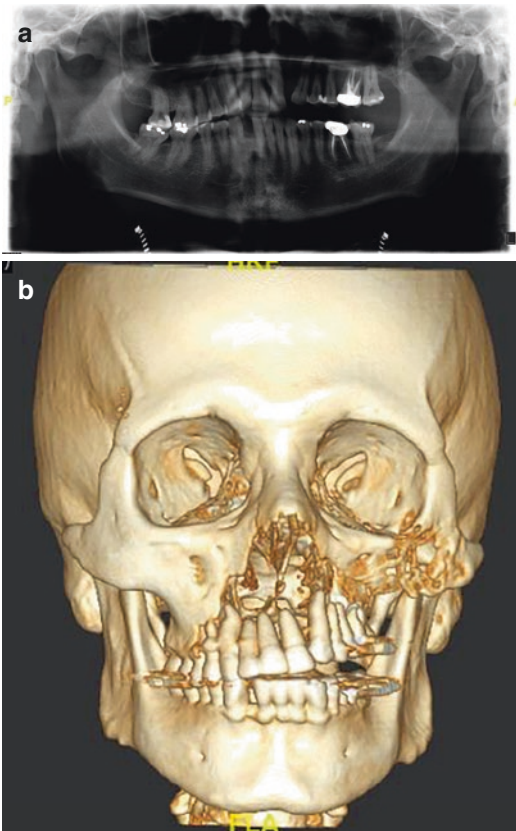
Gorham Stout syndrome—Left facial skeleton with maxillary and zygomatic bone osteolysis. (a) Orthopantomograph (b) 3D reconstruction of the CT scan
